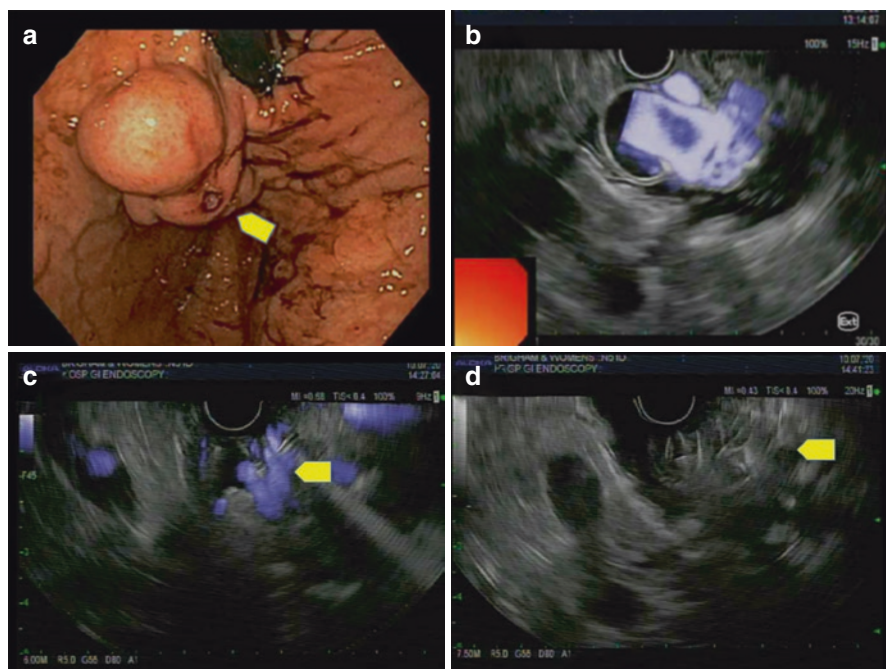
Endoscopic and EUS images of Bleeding IGV-1. (a) endoscopic view of IGV-1 with stigmata; (b) EUS view of GV with baseline Doppler flow assessment; (c) Extrusion of the initial coil with diminution of Doppler flow; (d) EUS appearance of intravascular coil + tissue adhesive, no Doppler flow seen
